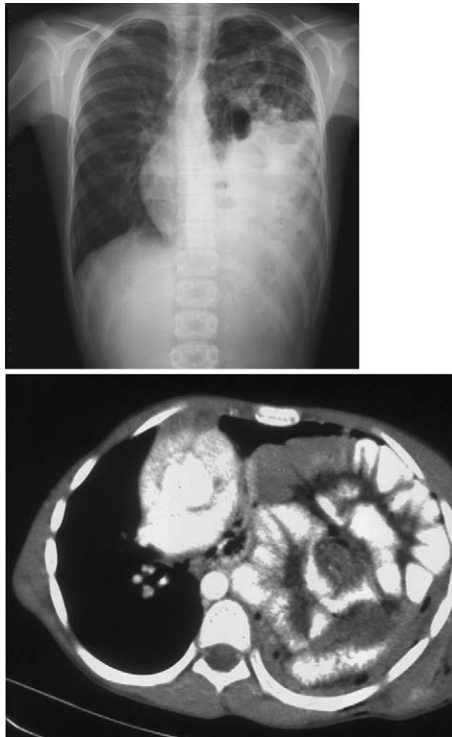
Preoperative chest X-ray showing a mass-like opacity suggesting bowel loops in the left hemithorax and mediastinal displacement to the right. Thorax computed tomography scan revealing mediastinal shift, total lung atelectasis and location of intra-abdominal organs in the left hemithorax.
